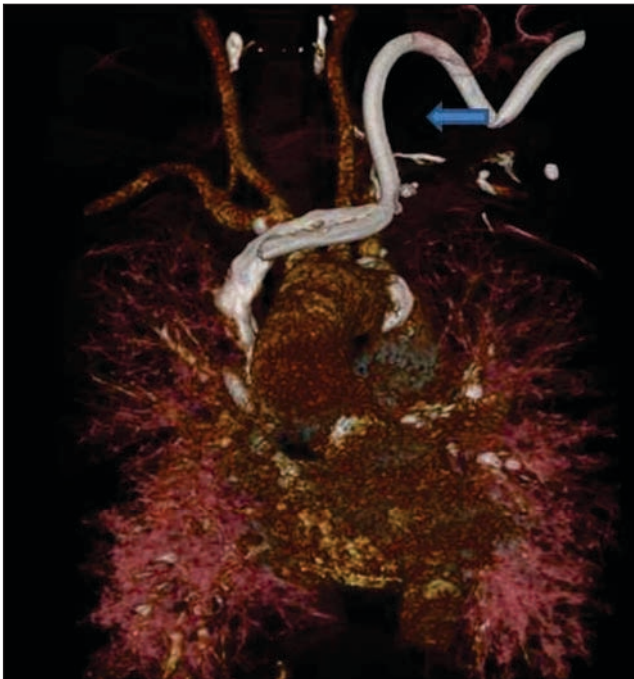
and 2B: CT scan of the thorax was performed that showed permcatheter tip outside the vascular lumen as a result of puncture of left brachiocephalic vein with subsequent migration into the anterior mediastinum
